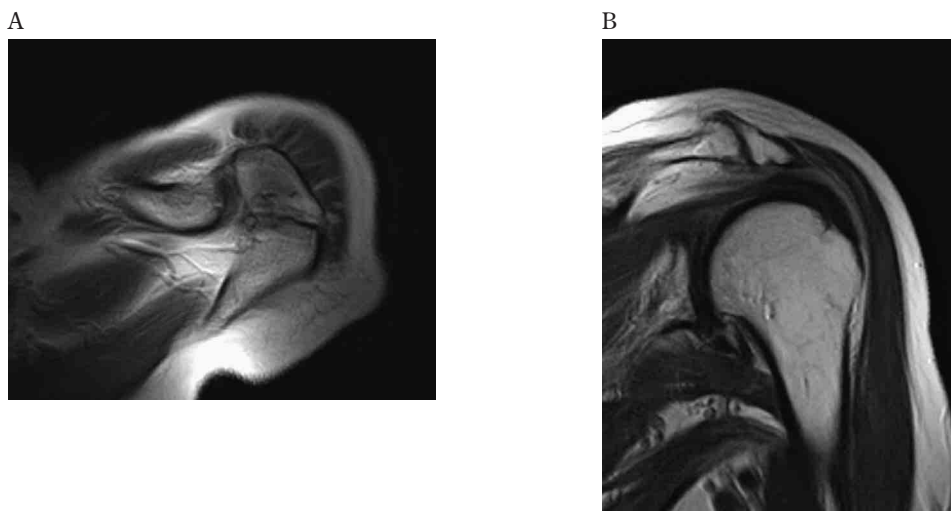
Magnetic resonance imaging in an elderly patient with *os acromiale* of the left shoulder. T2-weighted axial image (A) and T2-weighted oblique coronal image (B) clearly demonstrate the *os acromiale* with irregular margins. There was no fluid-like signal within the interface. The rotator cuff is not torn.
